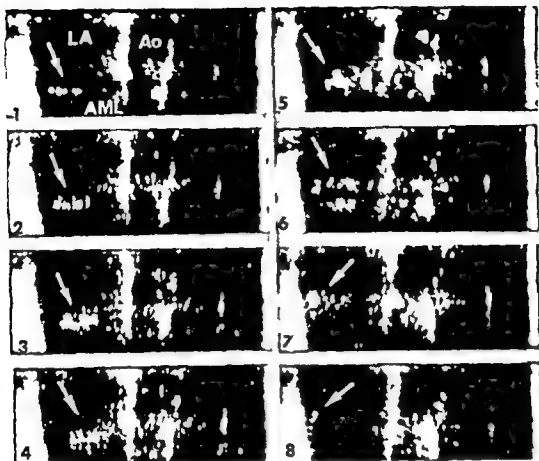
Selected frames (5 cm \times 12 cm) from the ultrasonic cross sections obtained along the long axis of the heart (1) (2) Highly mobile peripheral tumor (arrow) is seen in the left atrium (LA) measuring 2 cm in diameter. There is no pedicle attached to the thrombus. The motion of mitral valve is decreased and the LA was enlarged (3) (4) The tumor is approaching the mitral valve orifice (5) The tumor is obstructing the valve orifice during diastole (6) (7) (8) The tumor moves back quickly to the LA at the beginning of the ventricular systole. AML = anterior mitral leaflet. Ao = aorta.
